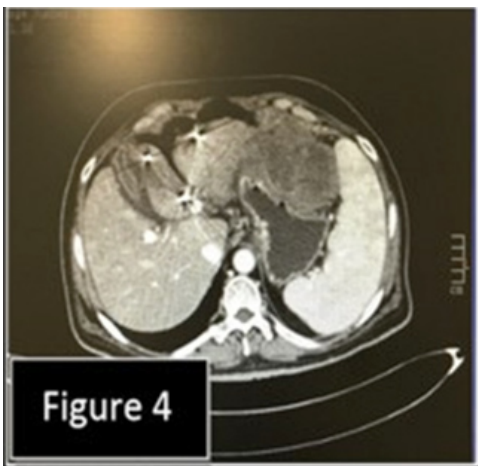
Triple Phase normal end expiratory planning CT scan.
